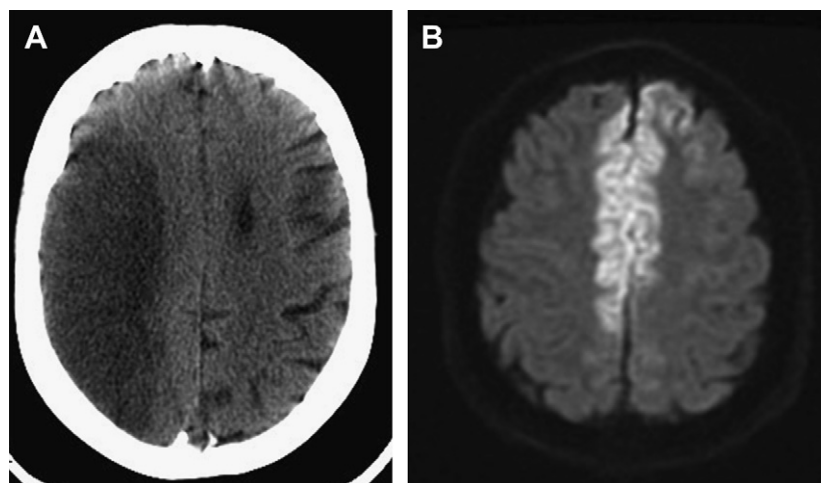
(A) Noncontrast computed tomography (CT) scan demonstrating infarction of the vascular territory of the right middle cerebral artery. Note the relatively unaffected cerebral tissue supplied by the anterior cerebral artery frontally and in the midline. (B) Diffusion-weighted image of an acute infarction of the anterior cerebral artery bilaterally. These images show the different areas of brain supplied by the anterior and middle cerebral arteries and the lack of collateral supply between major vascular divisions.
